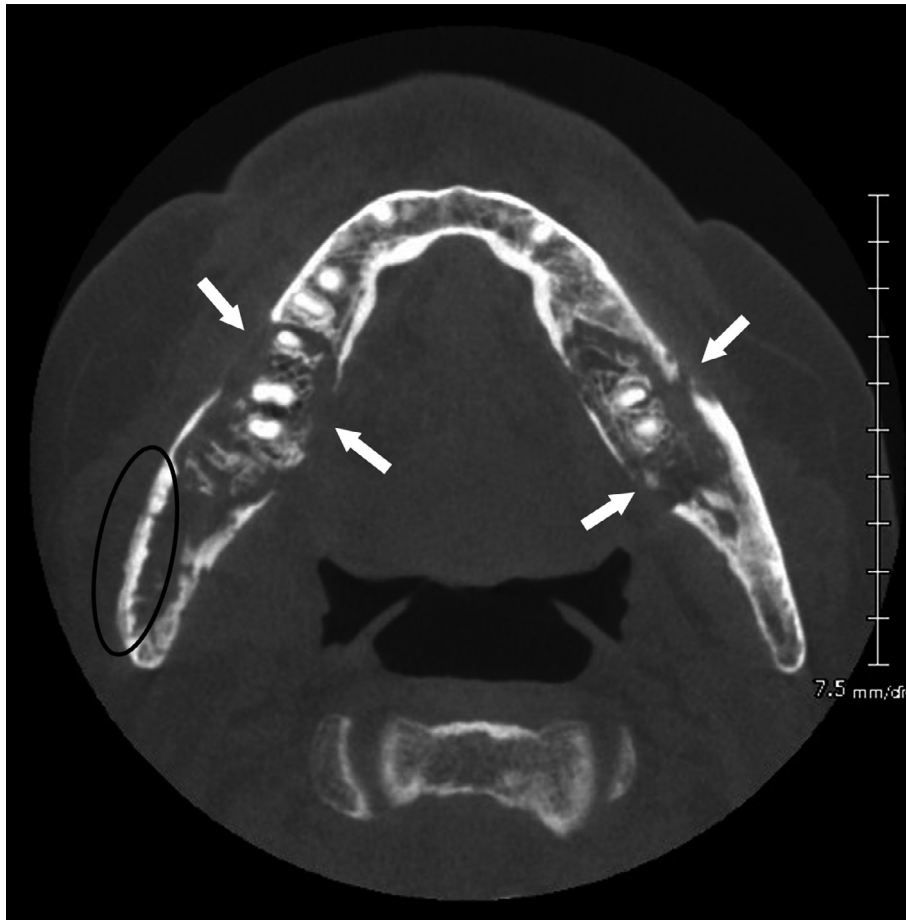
A 68-year-old male diagnosed with MRONJ with a history of lung cancer and developed bone metastasis. An axial CT image shows cancellous sequestra on both sides of the mandible with buccolingual cortical perforation (arrow). Periosteal reaction is also detected on the right posterior part of the buccal cortical bone (circle). MRONJ, medication-related osteonecrosis of the jaw.
